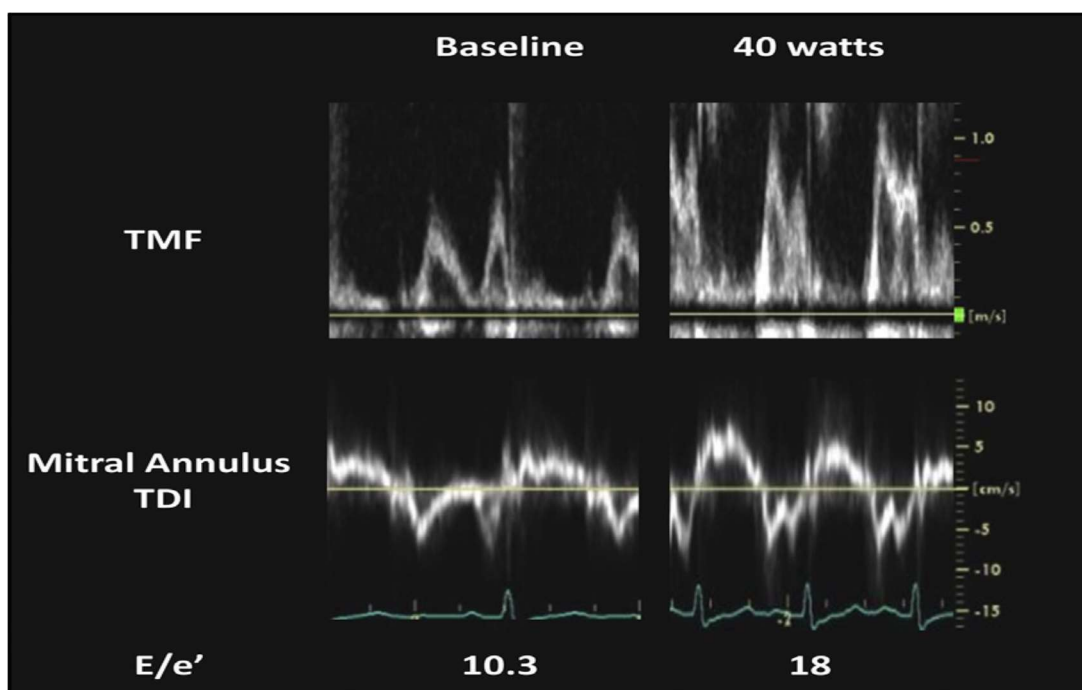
Diastolic stress echocardiography in a typical scenario. TMF and mitral annular tissue Doppler velocities were measured at rest and during 40 W supine ergometer exercise in a patient with invasively proven HFpEF (PCWP during exercise, 27 mm Hg). At baseline, transthoracic echocardiogram shows normal E/e' (average 10.3), normal EF (70%), normal LA volume index (30 mL/m²), and an estimated RVSP of 28 mm Hg. The E/e' ratio rises when exercise up to 40 W generates a significant increase in mitral E without a noticeable change in e'. The tricuspid regurgitant velocity increases from 2.5 to 3.5 m/s during exercise. TDI stands for tissue Doppler imaging.
